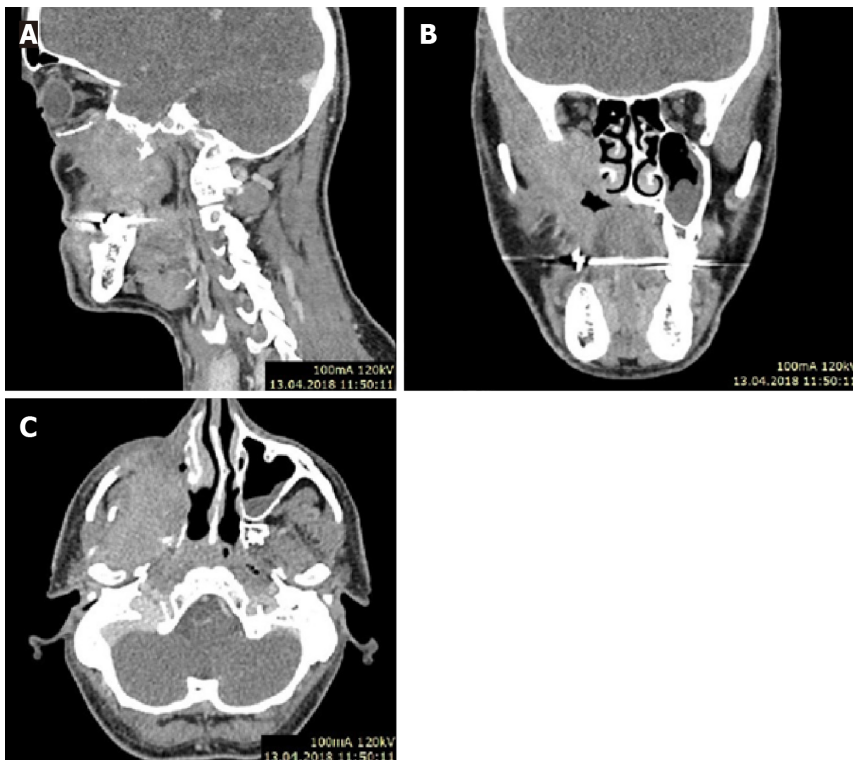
Case 2 computed tomography with contrast scan. Solid contrast-enhancing tumor filling the maxillary sinus is shown. A: Sagittal section; B: Coronal section; C: Axial section.
